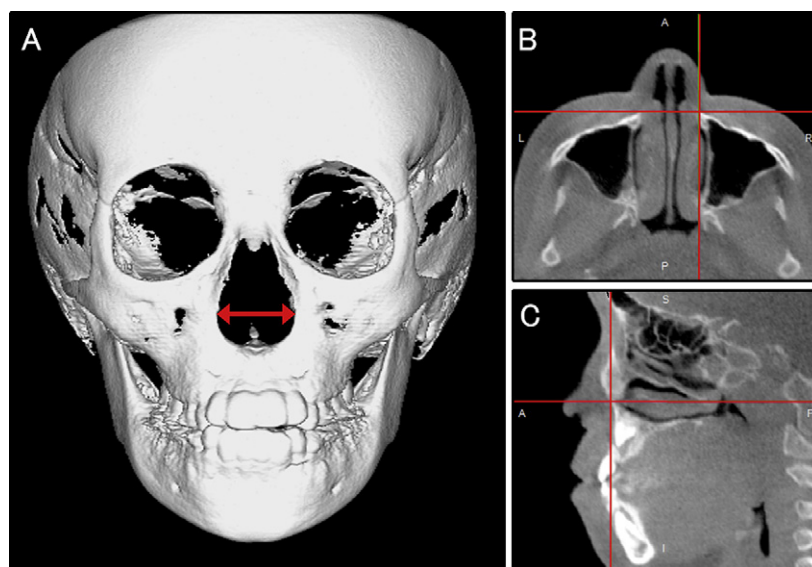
Measurement of 3D nasal width: A, locating the widest portion of the nasal aperture in a 3D computed tomography reconstruction to set the measurement points in the B, coronal and C, sagittal section images.
